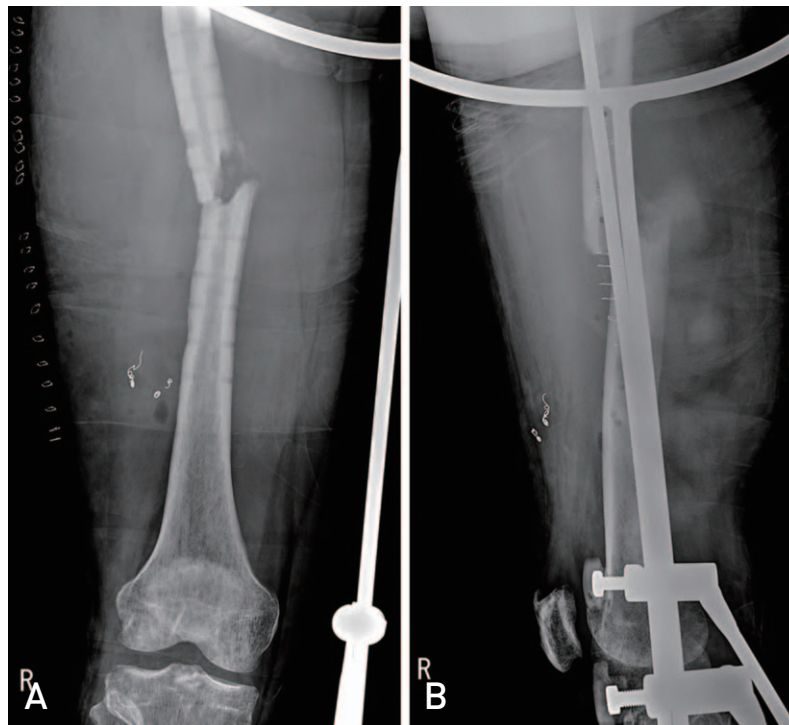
He slipped and suffered a fall four months ago and underwent an operation for a right femoral shaft fracture at a local medical center. (A) Preoperative X-ray and (B) immediate postoperative X-ray at a local medical center.
